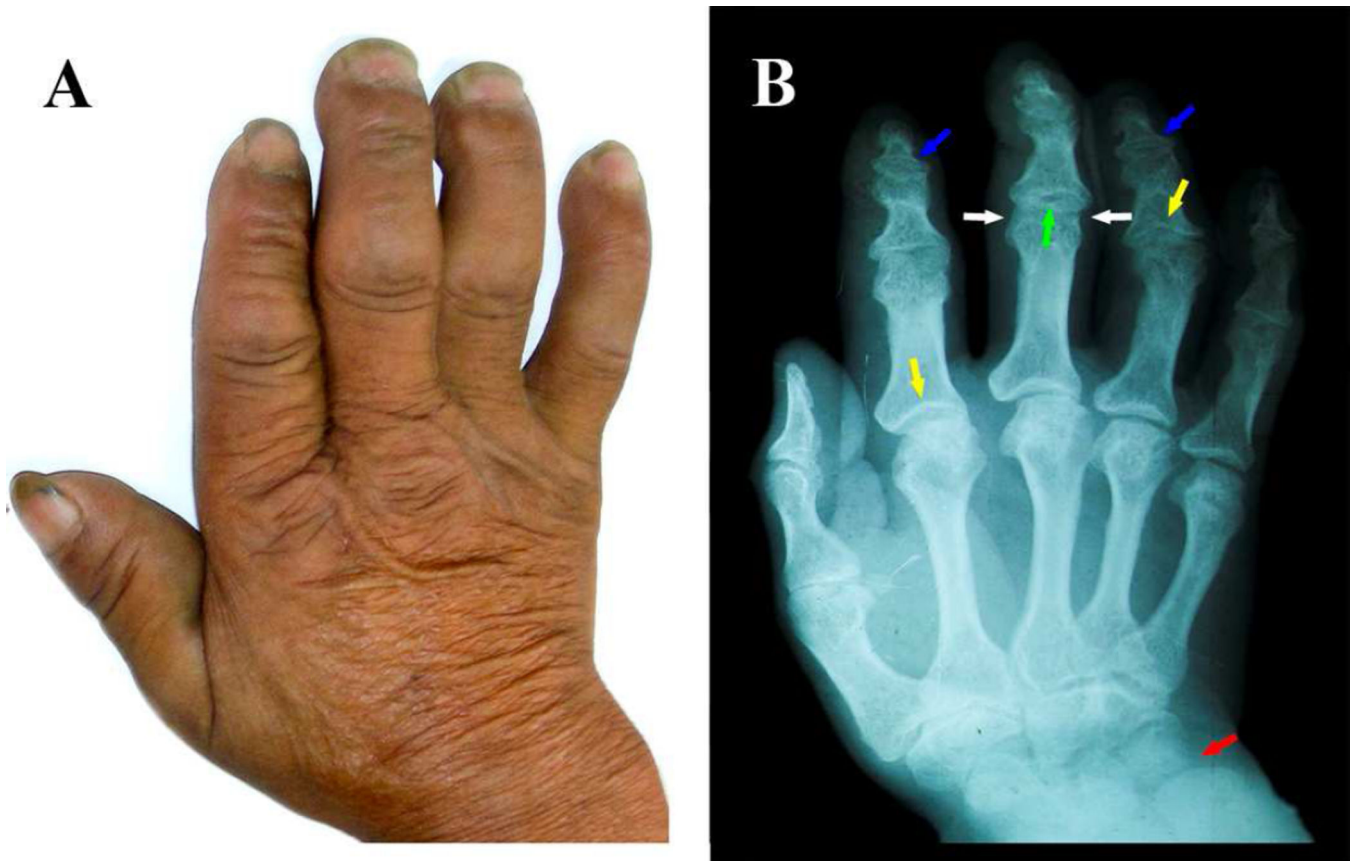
Hand radiographic features of KBD and the four criteria used for diagnosing adult KBD
